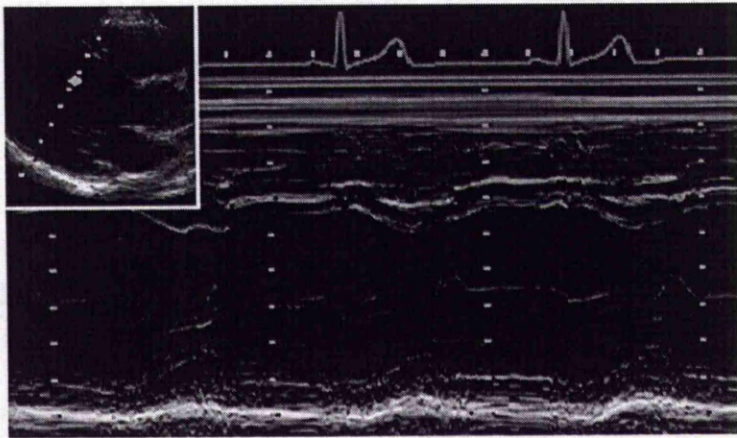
Parasternal long axis view showing the septum and the posterior wall.
